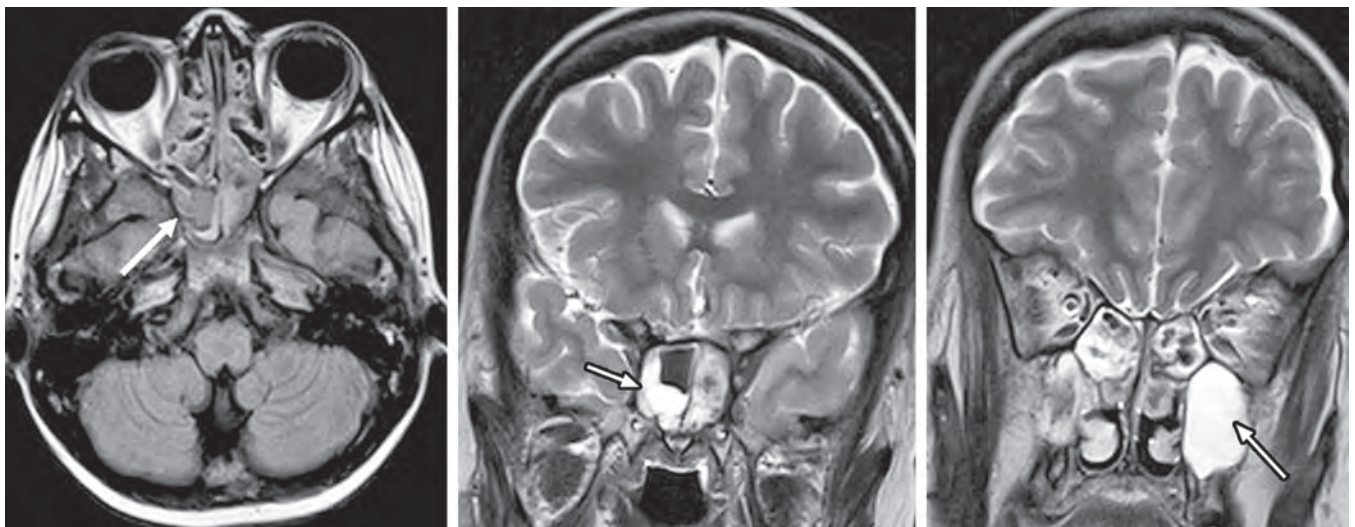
MRI of the brain showing evidence of fungal infection in the ethmoidal and maxillary sinuses (arrows). Infection is limited to the sinuses and not involving the dura or extending intracranially (Stage I)
